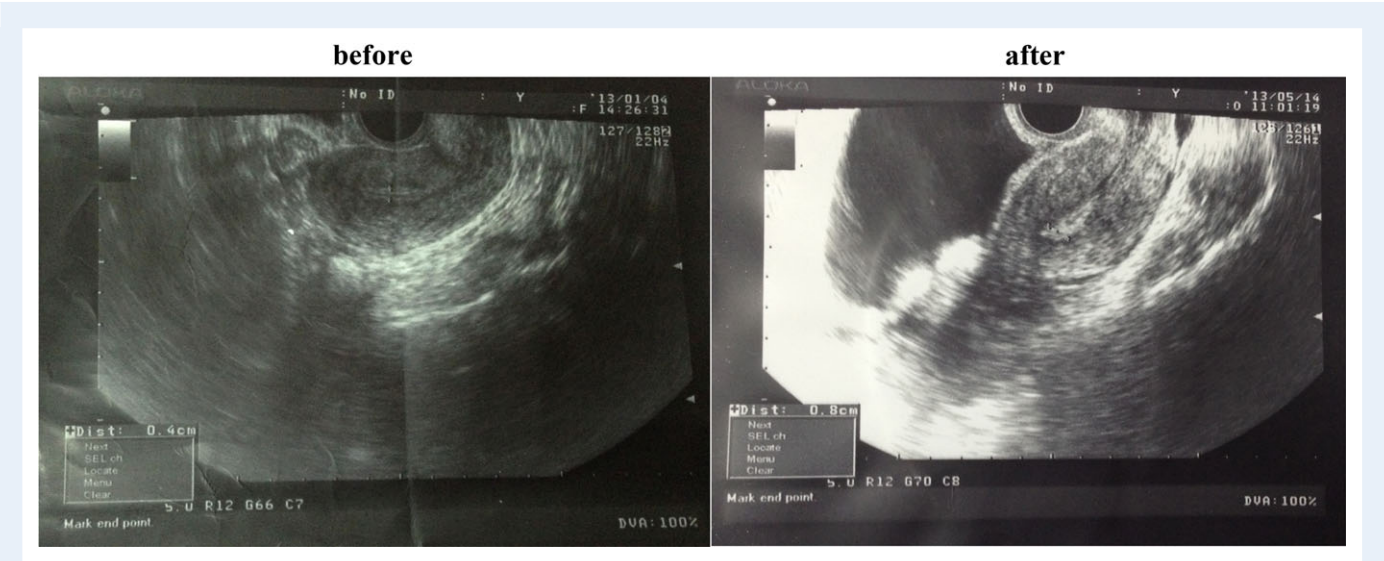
Transvaginal ultrasonography of the uterus before and after menSCs transplantation in Patient 3.
